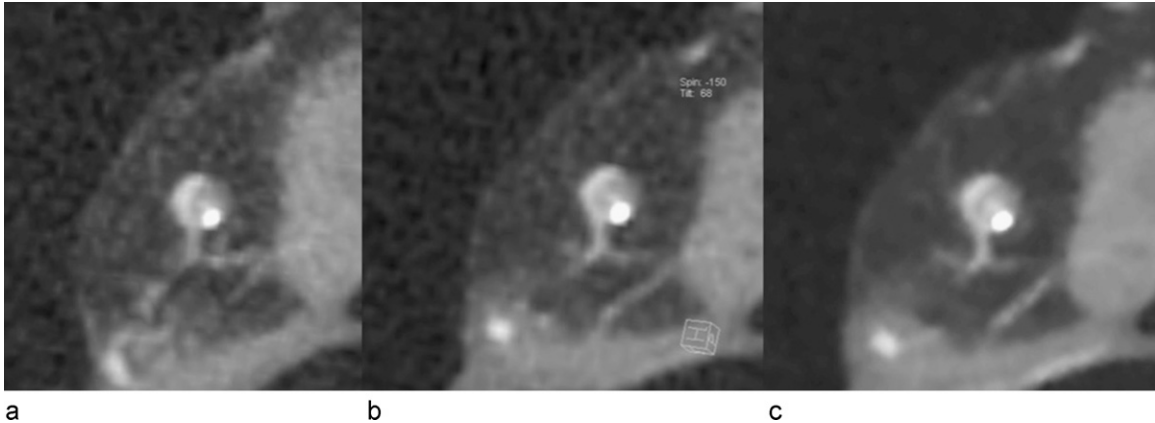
Cross-sectional CT images of a partially calcified atherosclerotic plaque.
